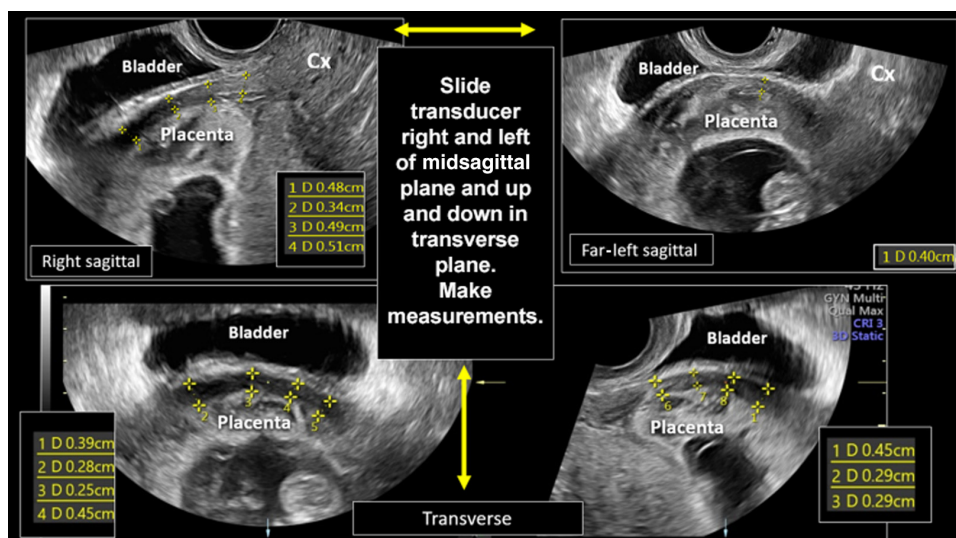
Grayscale transvaginal ultrasound images of Cesarean scar pregnancy, demonstrating importance of shifting vaginal probe right and left of midsagittal plane as well as up and down in transverse plane to obtain best measurement of residual myometrial thickness. Cx, cervix.
